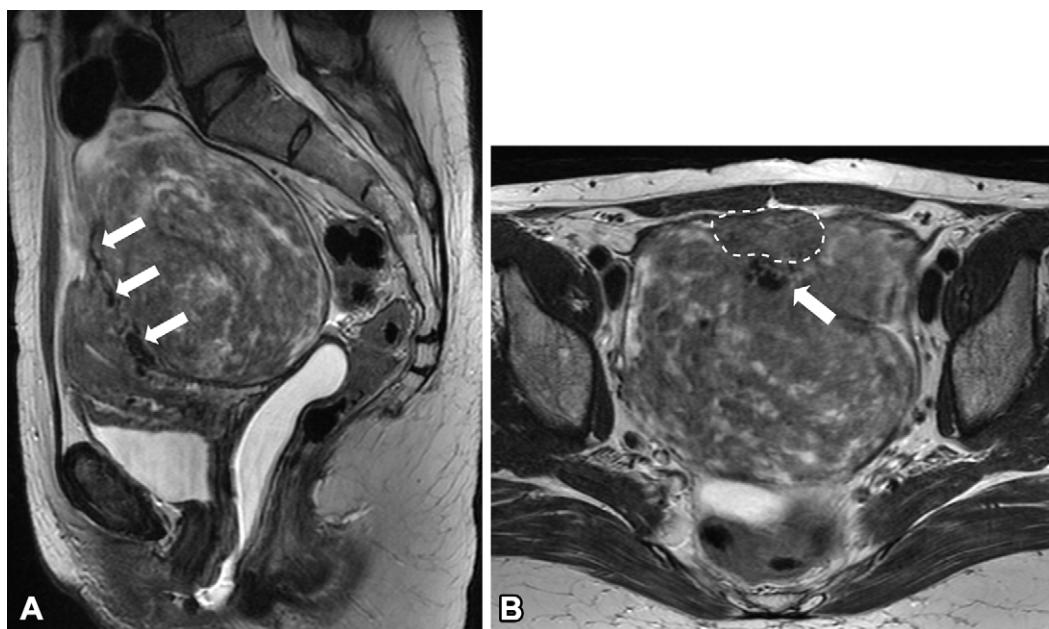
Large exophytic FIGO stage 7 myxoid subserosal leiomyoma in a 38-year-old woman who presented with pelvic pain. (A) Sagittal T2W MR image shows a T2 heterogeneous mass with bridging vessels that appear as T2-hypointense flow voids (arrows) between the mass and the posterior uterine body, compatible with their origin from the uterus. (B) Axial T2W MR image at the level of approximately the middle arrow in A shows the black flow voids, representing the cluster of uterine vessels bridging the uterine fundus anteriorly (arrow, dashed outline) and the leiomyoma posteriorly and laterally.
